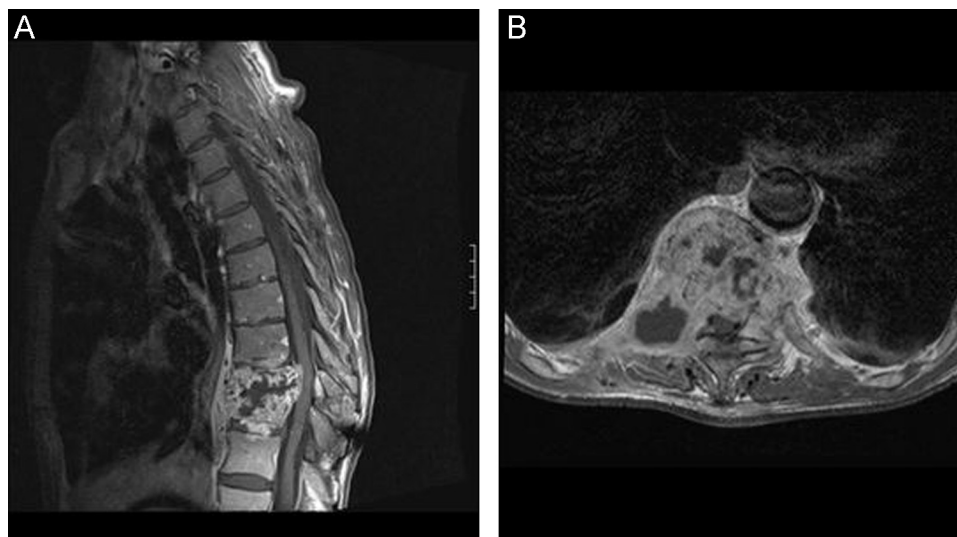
T1 MRI scans after first surgery showing bone block with necrosis, epidural abscess and spinal cord impression: (A) sagittal, (B) axial images.
